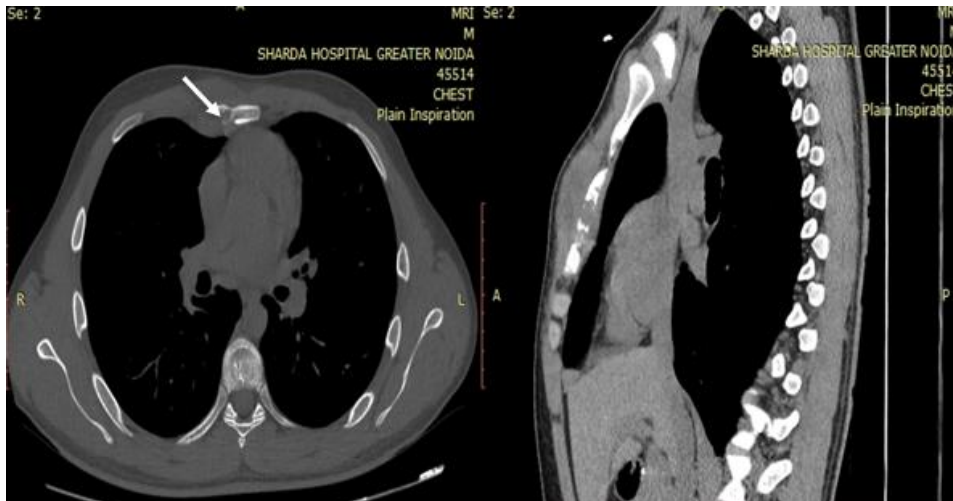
Axial and Right Parasagittal Non Contrast CT images reveal permeative lytic destruction of middle third of body of sternum with extruded sequestrum. Associated anterior soft tissue component in the form of hypodense collection and posterior retrosternal component are also noted (white arrows).
